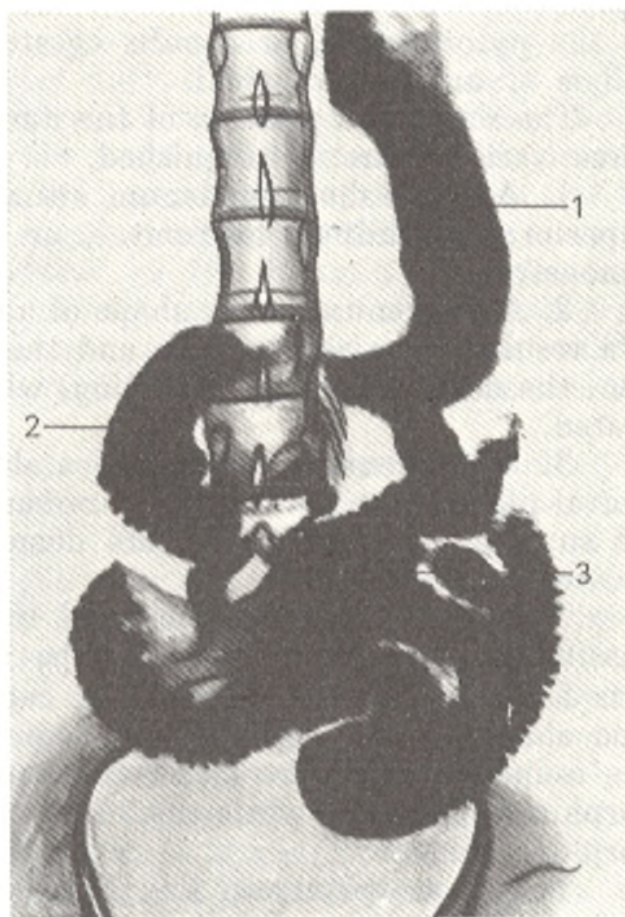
Radiograph of the gastro-intestinal tract.
